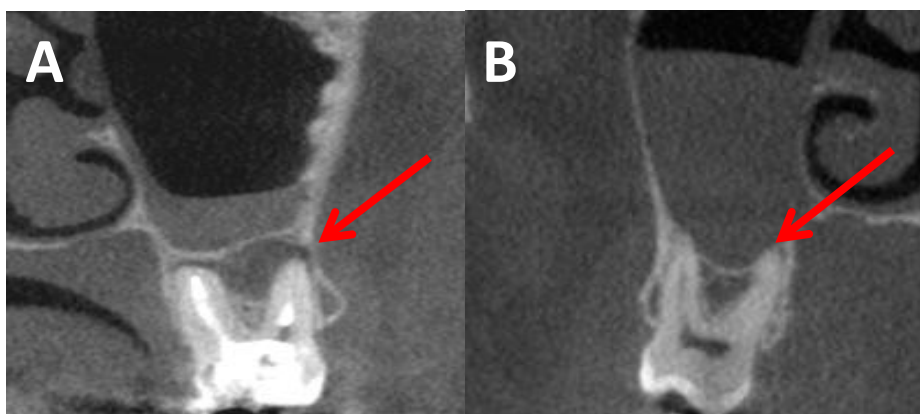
Corte coronal de TCFC mostrando: (A) - presença de lesão periapical no 2º molar superior esquerdo (seta vermelha); (B) – 1º molar superior direito justaposto ao seio maxilar sem lesão periapical, que respondeu de forma negativa ao teste de sensibilidade pulpar, durante o exame clínico.
